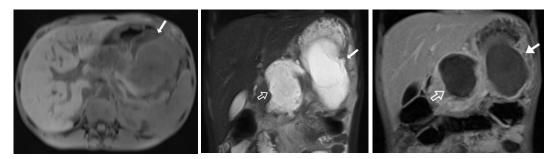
a, b, c. Magnetic resonance imaging (MRI) shows bilobular pseudocyst that is heterogeneously hypointense on axial T1-weighted (W) images (a), heterogeneously hyperintense on coronal T2W images (b), non-enhancing on post-contrast coronal T1A-weighted images (c) (arrows).
